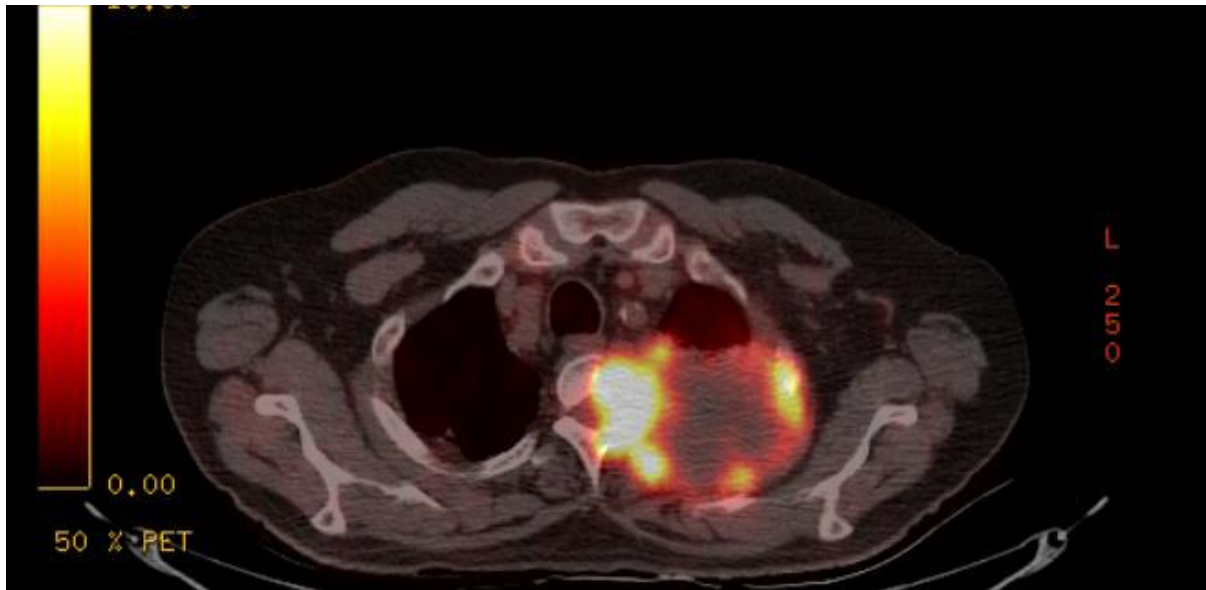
The first PET-CT scan of patient is seen. A mass involving left 1st to 3rd rib was detected in the apical segment of left upper lobe with 10 cm diameter. The tumor extends towards the spinal canal, destroys the ribs and in the left half of the T1-3 vertebrae (SUVmax: 14.1).
